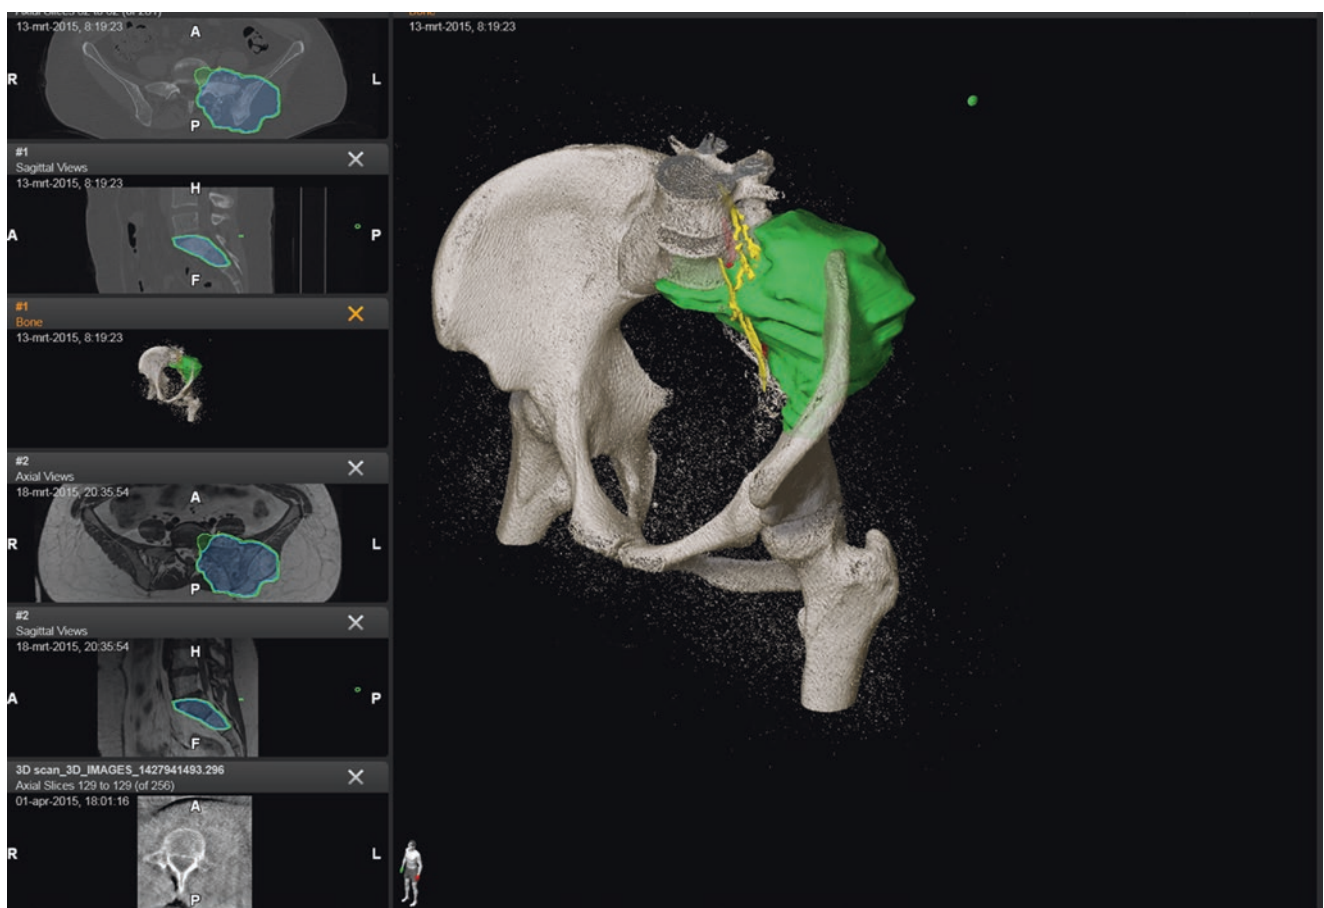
Large 3D volume render on the right of the pelvis, the tumour and overlying critical structures. On the left side, views from multiple imaging sets are visible. The tumour was segmented on the MRI visible in the #2 screens
